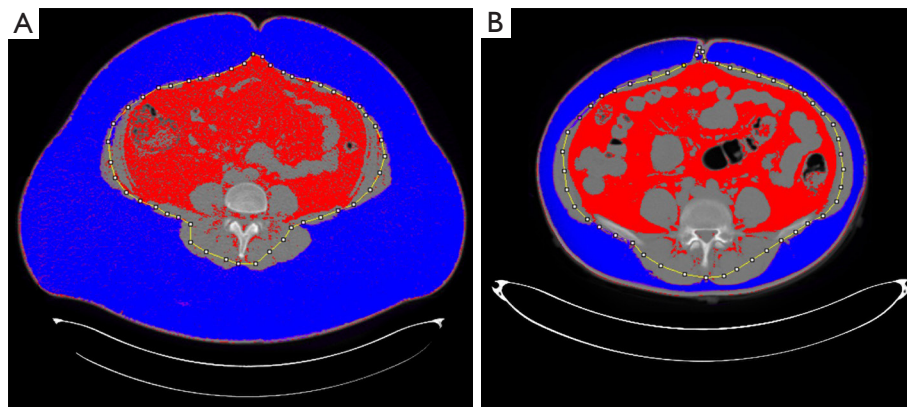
Fat measurements on CT images. Blue area: SFA; red area: VFA; yellow line: a linear structure drawn along the abdominal skeletal muscle. (A) CT image of a 32-year-old woman with a rVFA of 22.9% and a BMI of 48.9 kg/m². (B) CT image of a 43-year-old woman with a rVFA of 55.2% and a BMI of 32.0 kg/m². CT, computed tomography; SFA, subcutaneous fat area; VFA, visceral fat area; rVFA, relative visceral fat area; BMI, body mass index.
